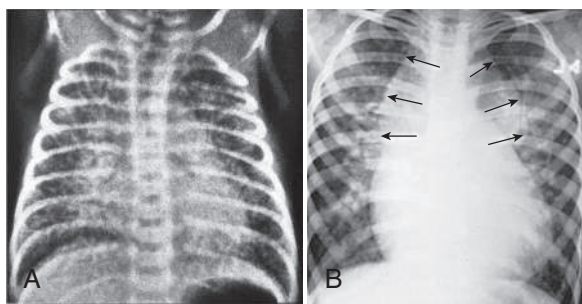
Chest radiographs of total anomalous pulmonary venous return (TAPVR). A, A newborn with TAPVR to a descending vein (below the diaphragm) with obstruction, showing marked pulmonary venous congestion and normal heart size. B, TAPVR to the left superior vena cava (preoperative image). Arrows point to the supracardiac shadow, which produces the "snowman" or figure 8 configuration. Cardiomegaly and increased pulmonary vascularity are evident.
